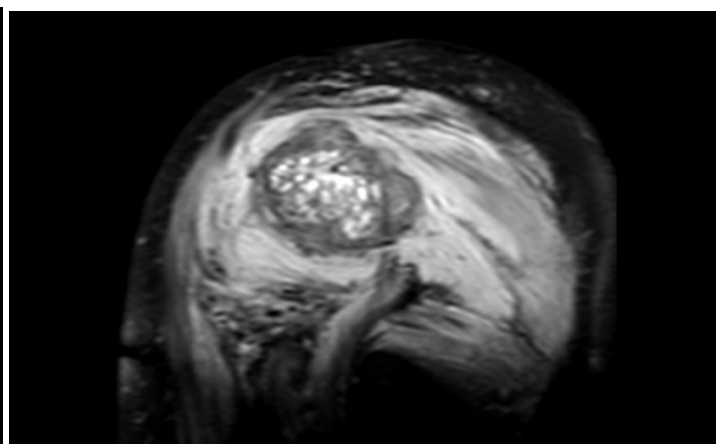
MRI T2-weighted image of left humerus. It shows hyperintense foci with significant muscle edema.
